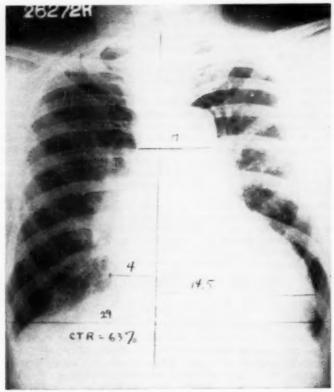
Roentgenogram of chest, 1943, showing accentuated vascular markings in the right hilar region. The heart is enlarged to the left.
